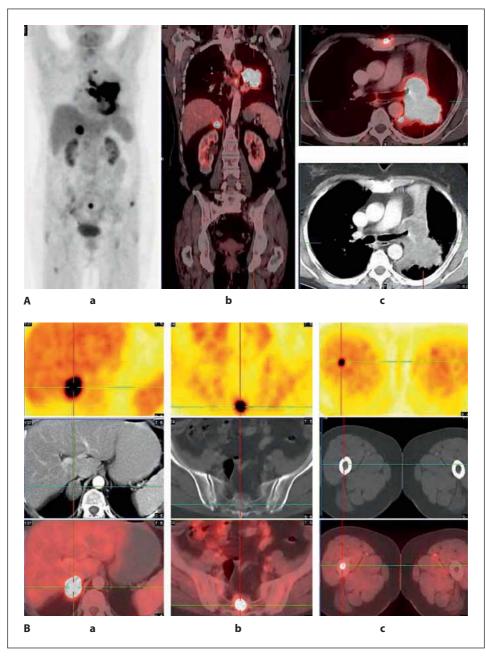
A Whole-body imaging by FDG-PET/CT – a 'one stop shop'. NSCLC (squamous cell carcinoma) of the left lung, centrally located (SUV_{max} 17.9; ϕ 8.8 cm) with right adrenal metastasis (SUV_{max} 12.5, ϕ 3.6 cm), lymph node metastasis and multiple bone lesions which were not appreciable on CT alone. a Maximum intensity projection (MIP) image. b PET/CT coronal slice. c Transversal slice (primary tumor). B Accurate localisation of adrenal lesion by fused FDG-PET/CT images (a). Often molecular changes precede morphological changes: bone metastasis demonstrated by FDG-PET without appreciable osteoblastic or osteolytic changes on CT (b, c).
